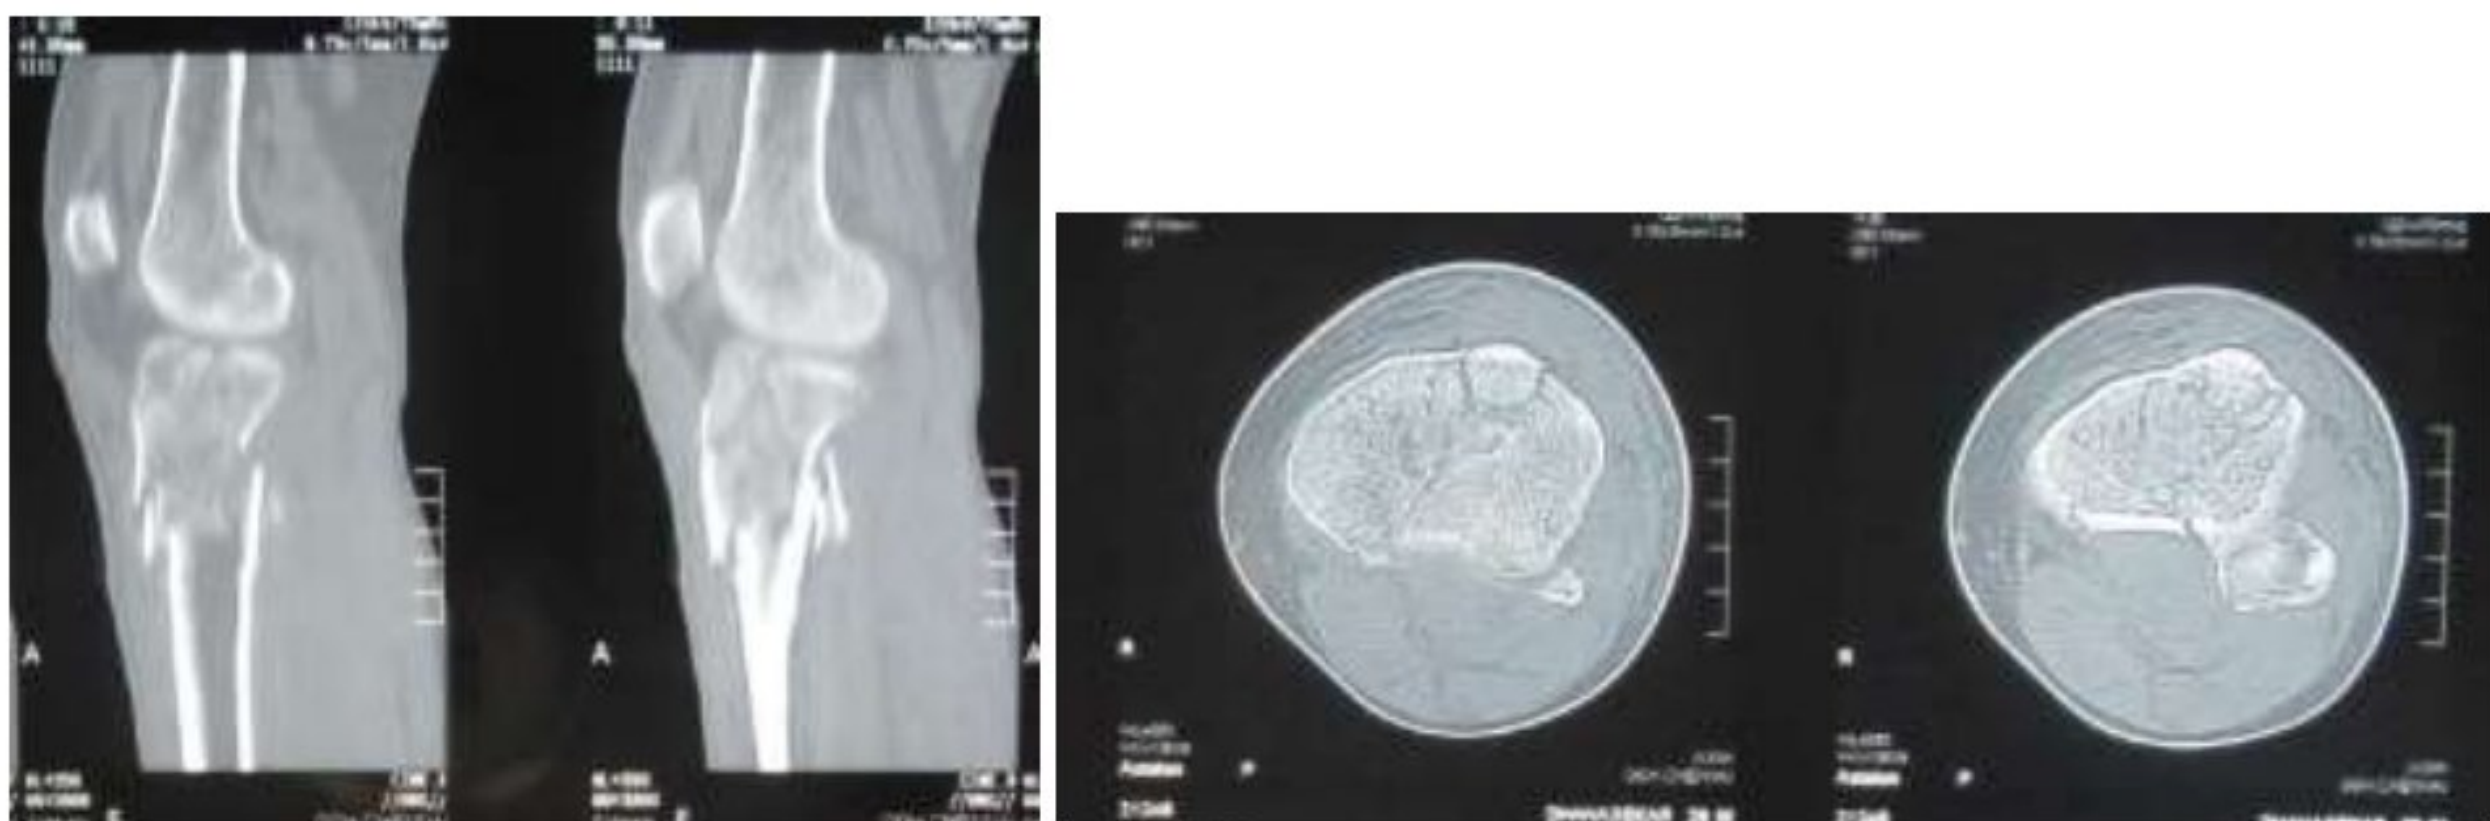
CT images: posteromedial fracture fragment
